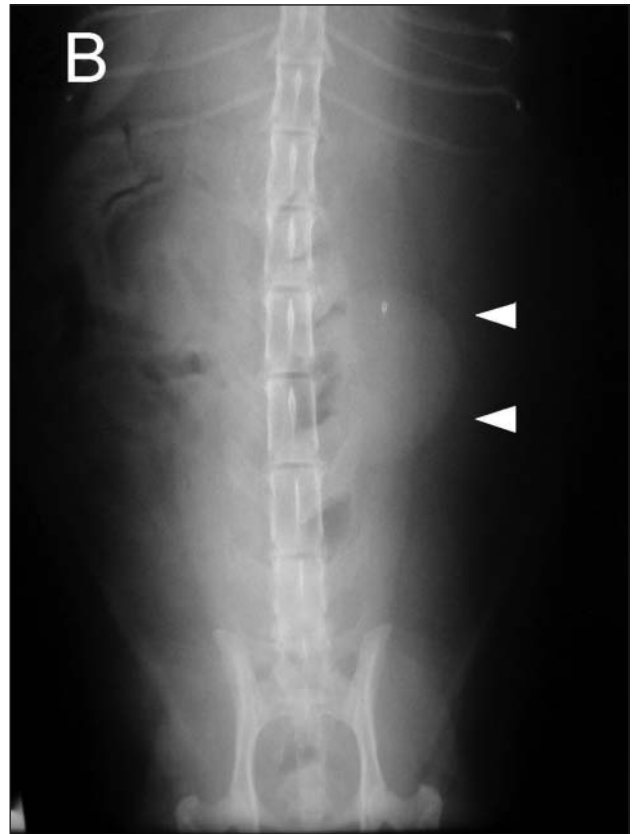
Same radiographic views as in Figure 1. On the lateral view, a round soft tissue mass is located external to the body wall ventrally just cranial to the hind limbs (arrow). A small amount of mottled soft tissue opacity indicative of fat surrounds the mass. On the ventrodorsal view, the mass is not visible. The left kidney appears to be normal in shape and size (arrowheads). The urinary bladder is not visualized within the abdomen, leading to the diagnosis of herniated urinary bladder.
